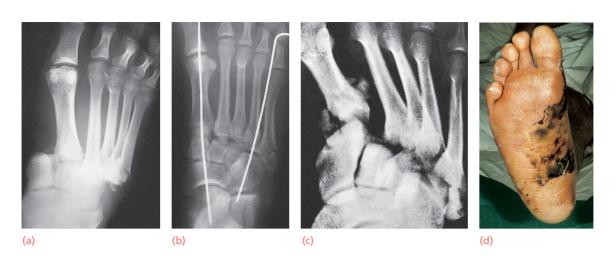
TMT injuries (a) Dislocation of the TMT joints. (b) X-ray after reduction and temporary stabilization with K-wires – later stabilization with screw fixation was performed. (c) X-ray showing a high-energy fracture-dislocation involving the TMT joints. These are serious injuries that may be complicated by (d) compartment syndrome of the foot.
